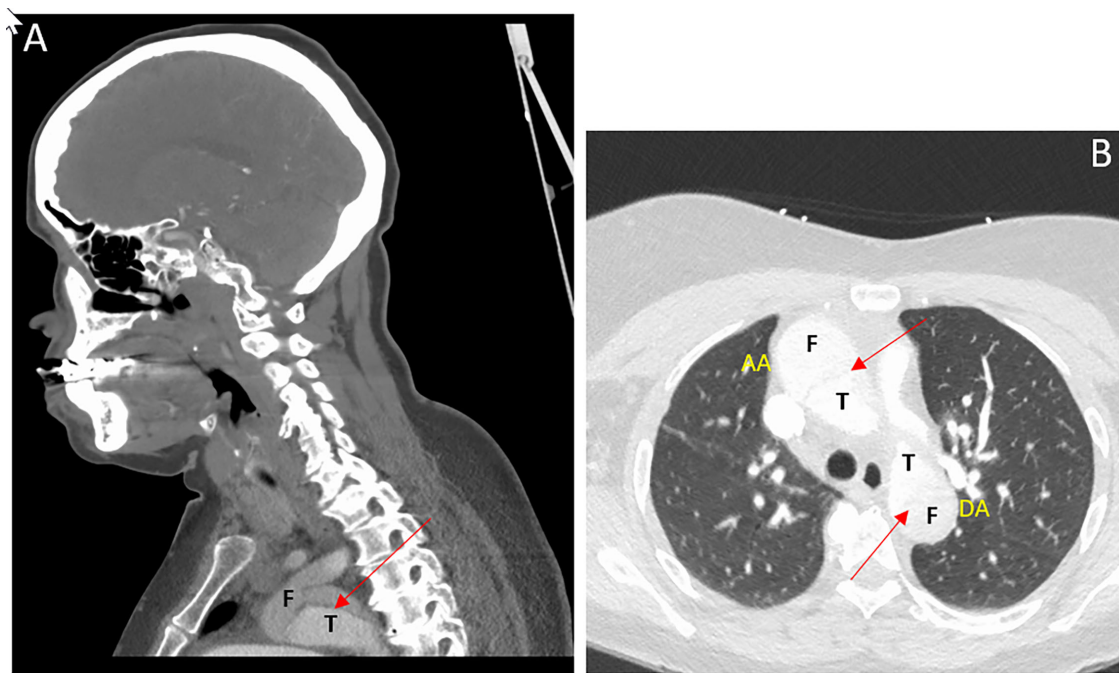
Computed tomography angiography of the head and neck demonstrating an aortic dissection involving the aortic arch (A) as well as the ascending and descending aortas (B). Red arrows indicate the dissection flaps. AA = ascending aorta; DA = descending aorta; F = false lumen; T = true lumen.
